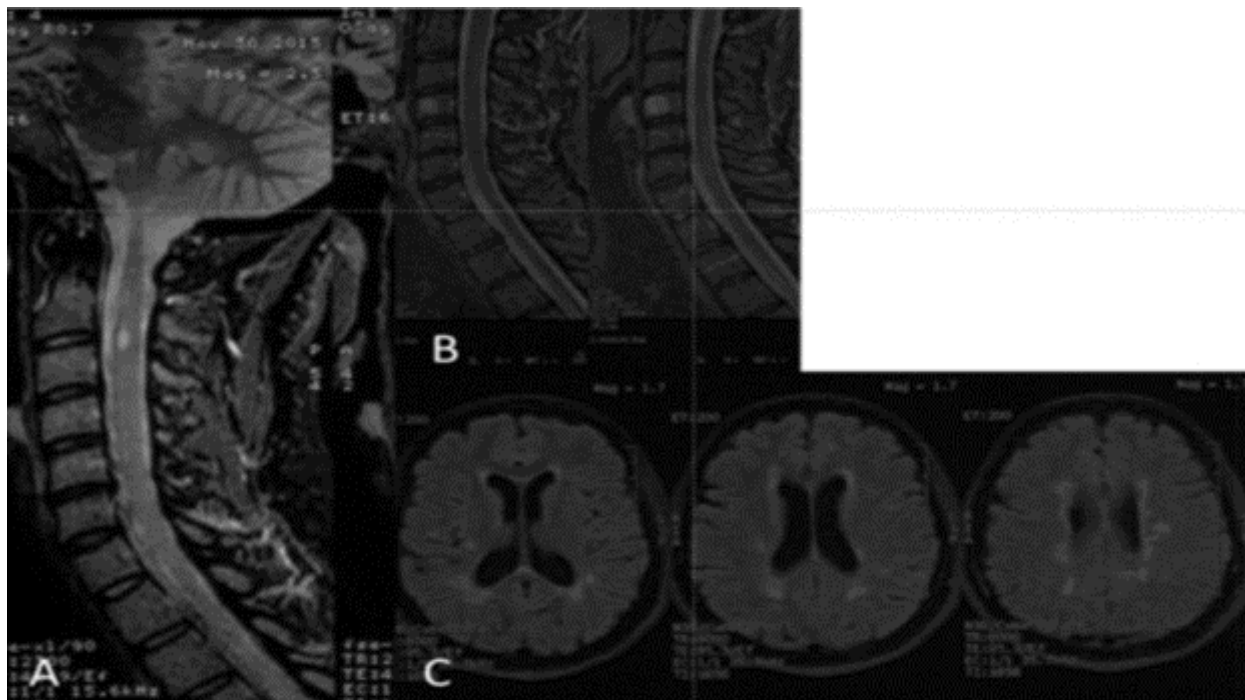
MRI showing spinal lesion before VZV infection. B) Longitudinally extensive transverse lesion extending from C7 to Th6. C) Brain MRI shows areas of hyperintensities perpendicular to the lateral ventricles.
